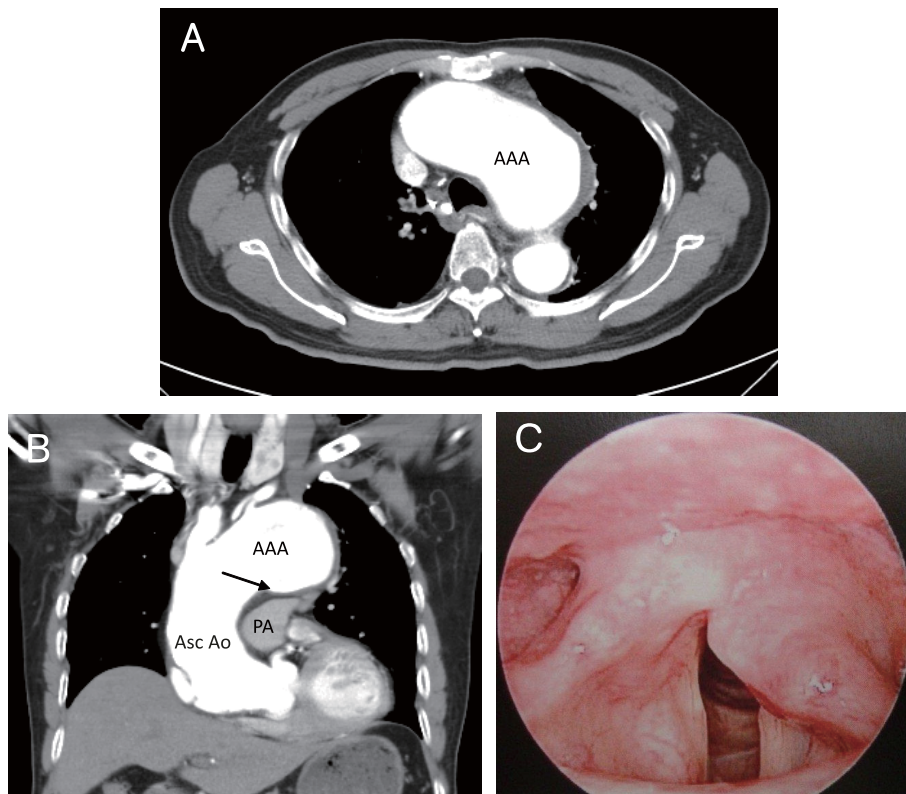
A & B: (A) Axial and (B) coronal views of contrast-enhanced computed tomography reveal a fusiform aneurysmal dilation with a maximal width of 7.7 cm over the ascending aorta and aortic arch, which caused aortic window narrowing and tracheal deviation. The aortic arch aneurysm is bulging to the aorticopulmonary window (arrow) near to where the left recurrent laryngeal nerve passes. PA = pulmonary artery; Asc Ao = ascending aorta; AAA = aortic arch aneurysm
